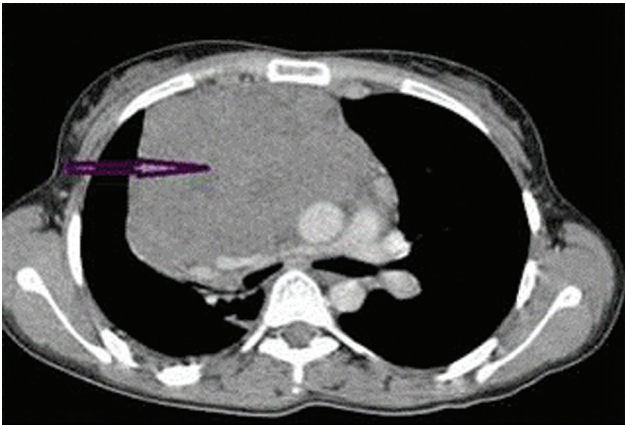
Axial contrast-enhanced computed tomography image demonstrating lobulated heterogeneously enhancing anterior mediastinal mass (arrow) on right side suggesting a diagnosis of Hodgkin's lymphoma.
